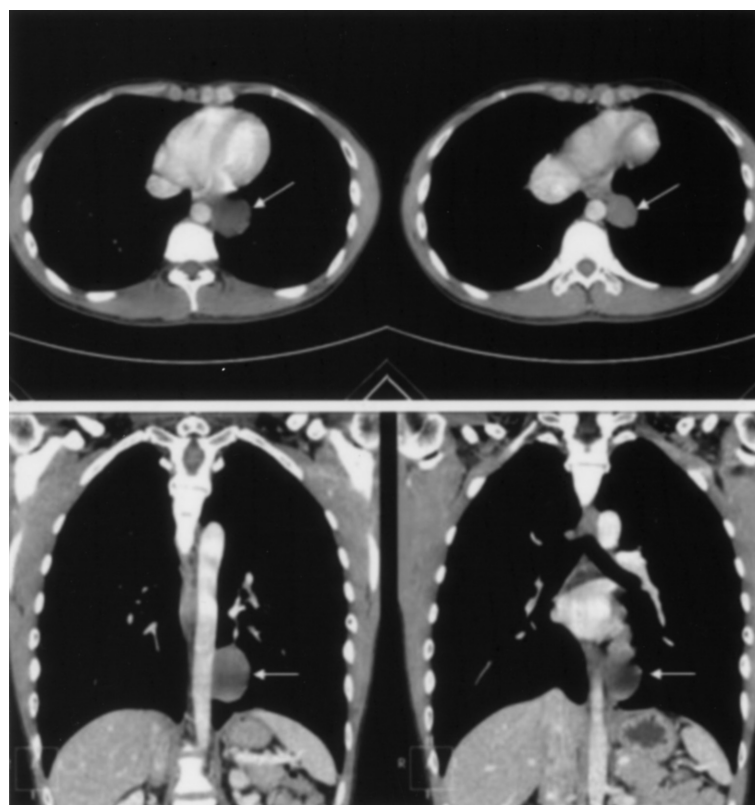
Enhanced computed tomography of the lower thoracic level shows an ovoid, well-defined, non-enhanced and iso-dense (about 53 HU) cystic lesion sized 3.2 x 3.0 x 4.4 cm (white arrow) [The upper row: axial image; The lower row: coronal reformation]
